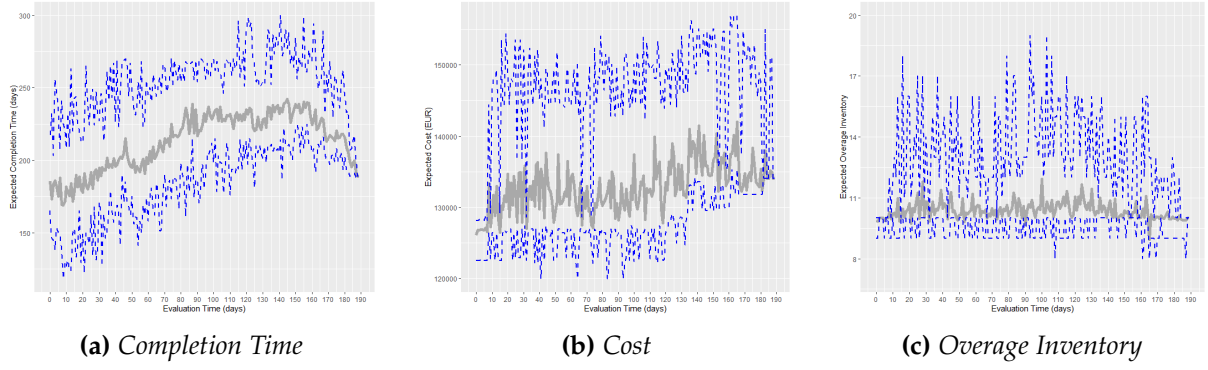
Evolution of estimations for key indicators of CT BP30002 using the S40K10 model
